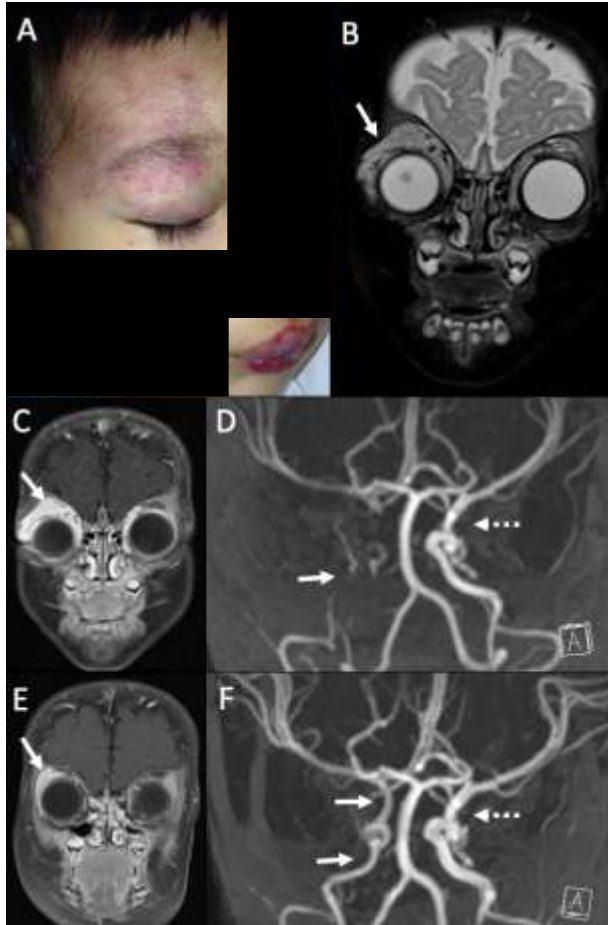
(a) Telangiectatic patch over the right periorbital, forehead, and lips, which then progressed to redness and swelling. (b) Coronal T2-weighted image with fat suppression and (c) post-contrast T1 weighted image, at the age of three months show the right orbital hemangioma (arrows). (d) Time-of-flight MRA of the proximal intracranial arteries shows absence of the right internal carotid artery (arrow) compared to normal left internal carotid artery (dashed arrow). (e) At the age of six months, after treatment with propranolol, the right orbital hemangioma shows an interval reduction in size (arrow), with (f) marked improved recanalization of the right internal carotid artery (arrows), although it remains smaller in caliber compared to the left internal carotid artery (dashed arrow).
